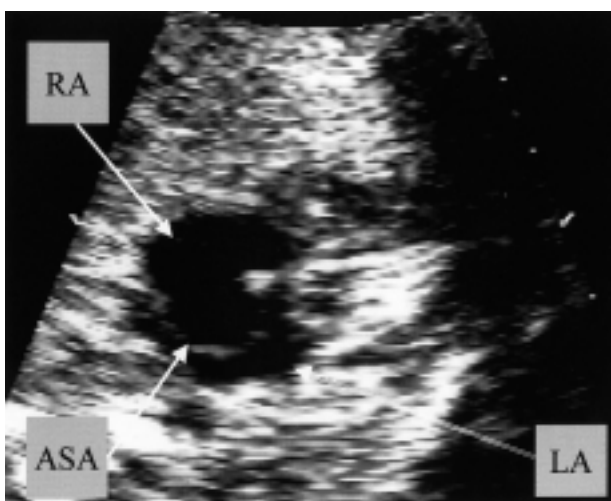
Two-dimensional echocardiography in the short-axis view of the atria of a fetus with an atrial septal aneurysm (ASA) bulging (white arrows) into the left atrium (LA). RA = right atrium.
